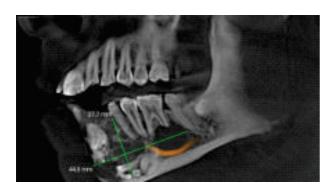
CBCT showing single well defined multilocular radiolucent lesion involving the anterior mandible extending from 43 to mesial aspect of 37 with multiple miniature tooth-like structure and associated with impacted 33
